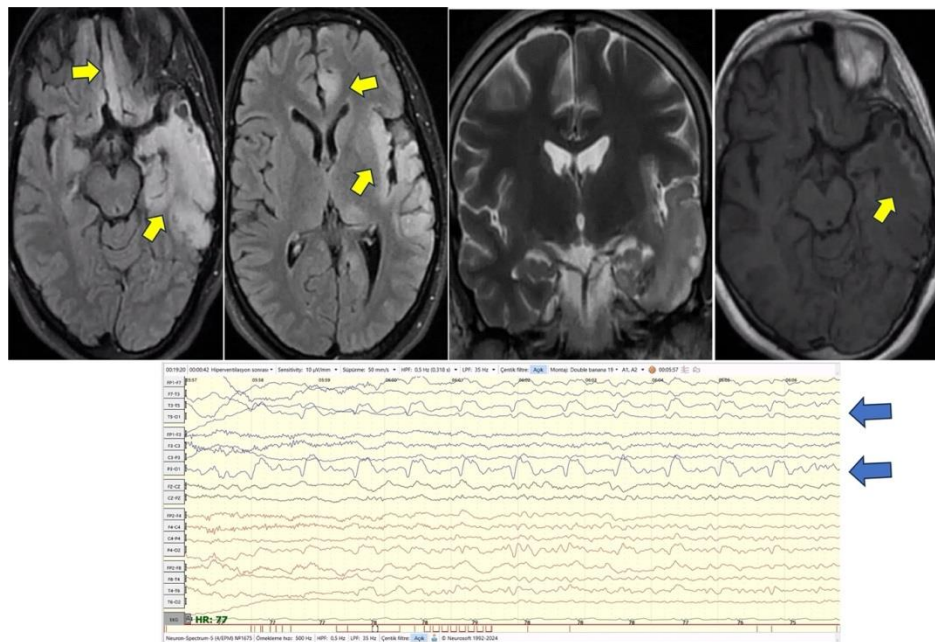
Cranial MRI and EEG examination of the second case at 6 weeks after HSVE. MRI showed that the lesion had developed mild hemorrhagic characteristics and exhibited contrast enhancement (yellow arrows). EEG demonstrated lateralized periodic discharges with a monomorphic blunt delta pattern in the left temporoparietal region (blue arrows).
